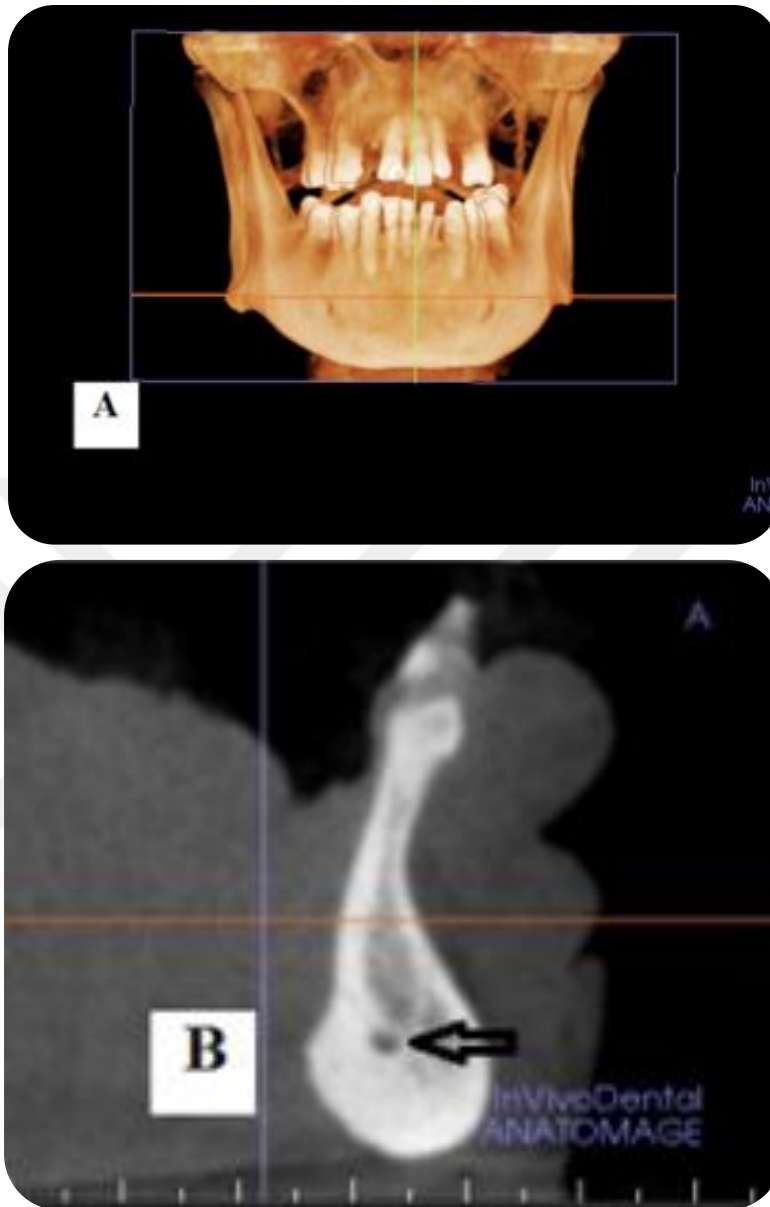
A: Volumetric 3-D representation of the mandible showing the level of the sagittal section slightly lateral to the midline. B: the cross- section of the same case lateral to the midline, showing the mandibular incisive canal (black arrow) denoted as a round radiolucent area surrounded by a corticated area (Images obtained with i-CAT® Model 17-19; CBCT Imaging Unit: InVivoDental5 Version 5.2 Anatomage, software); Dentomaxillofacial Radiology Department; Faculty of Dentistry-University of Yeditepe.
